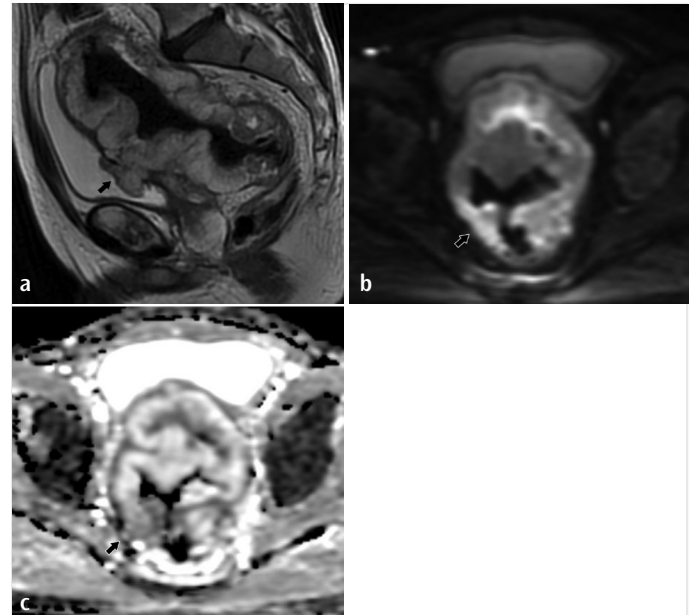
Giant rectal adenocarcinoma with bladder invasion (black arrow) and hyper-intensity on sagittal T2-weighted sequence.
